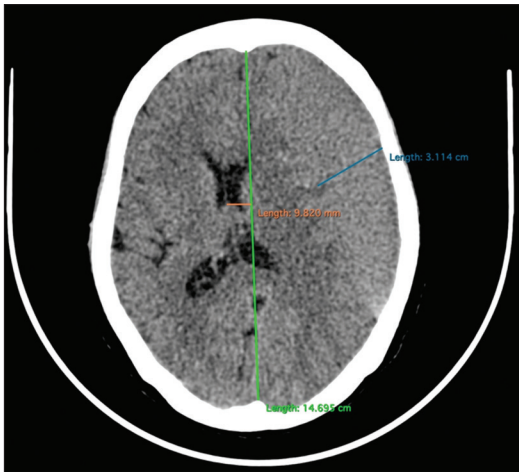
Computed tomography scan during the 1st day of hospital admission in National Brain Center. Chronic subdural hematoma thickness was 3.1 cm with a 9.8-mm midline shift
